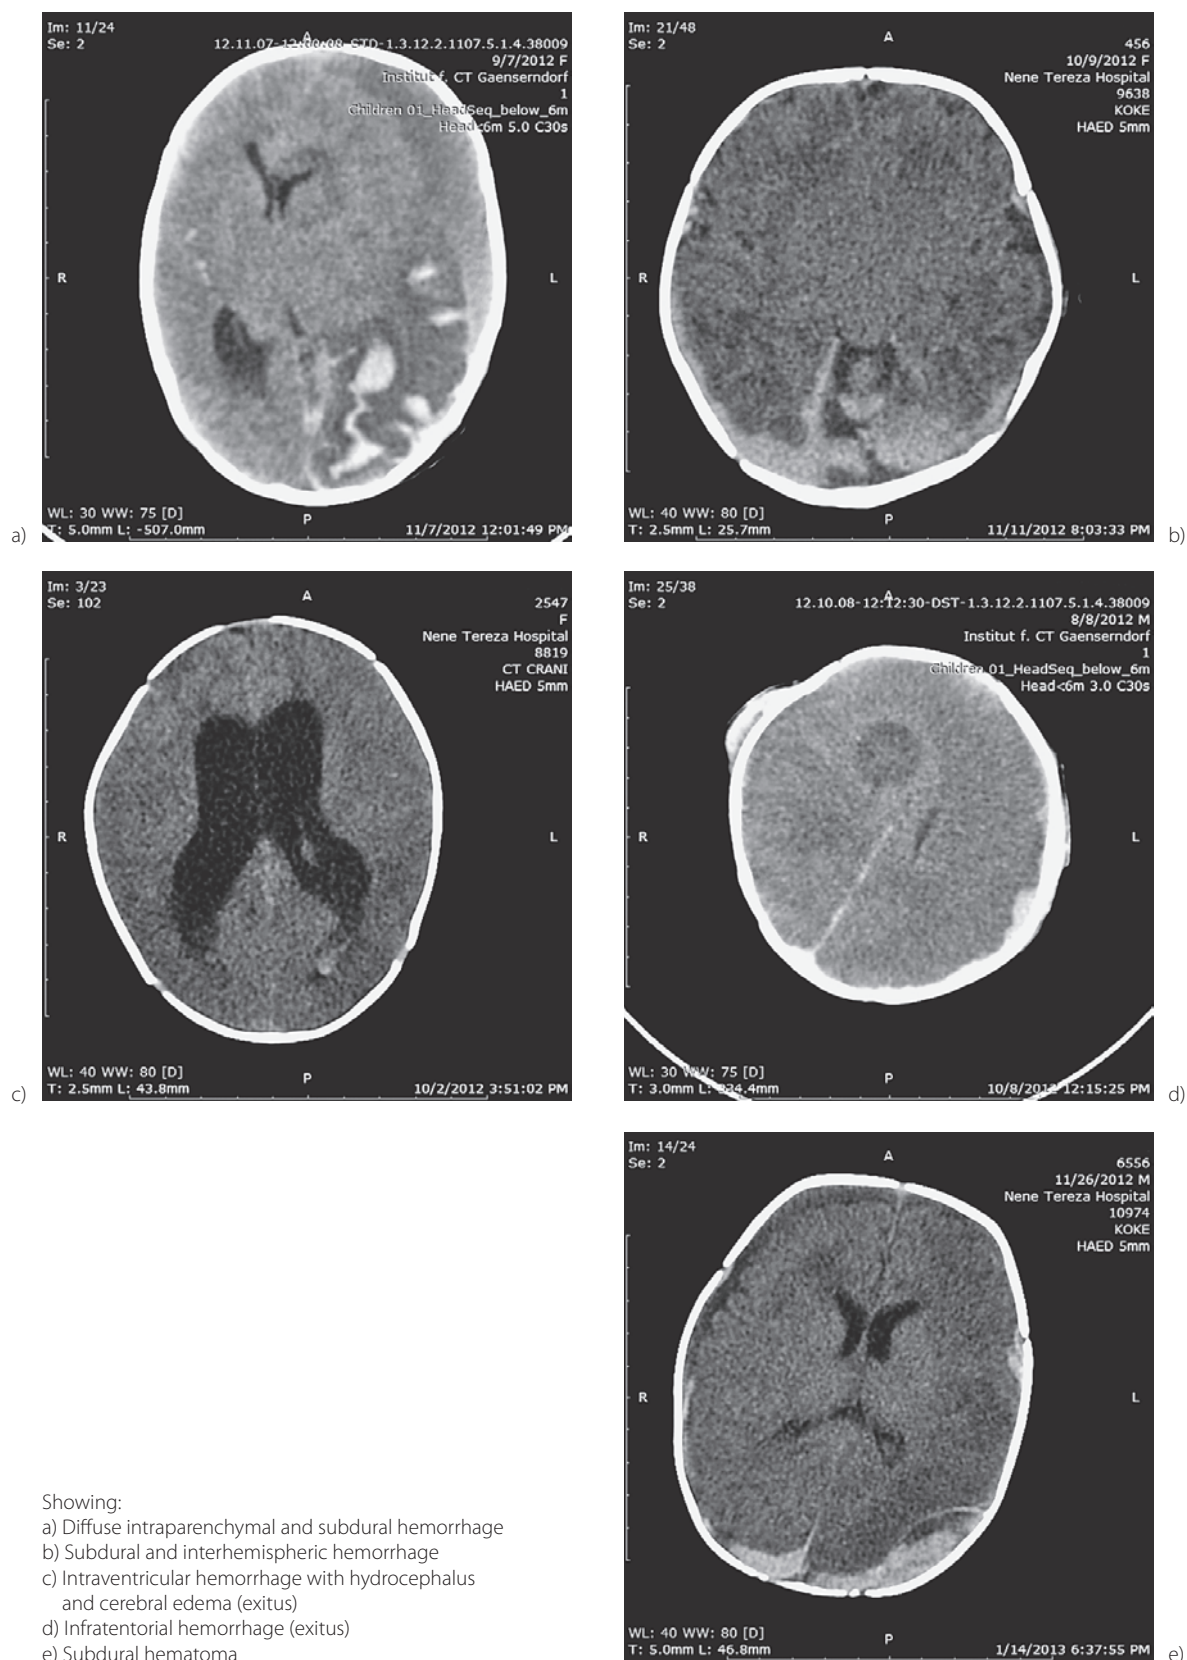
Radiologic findings in these infants with intracranial hemorrhage; computed tomography performed on day 1 of their admission to our Pediatric Intensive Care Unit revealed the following: (a) diffuse intraparenchymal and subdural hemorrhage; (b) subdural and interhemispheric hemorrhage; (c) intraventricular hemorrhage with hydrocephalus and cerebral edema (exitus); (d) infratentorial hemorrhage (exitus); and (e) subdural hematoma.
